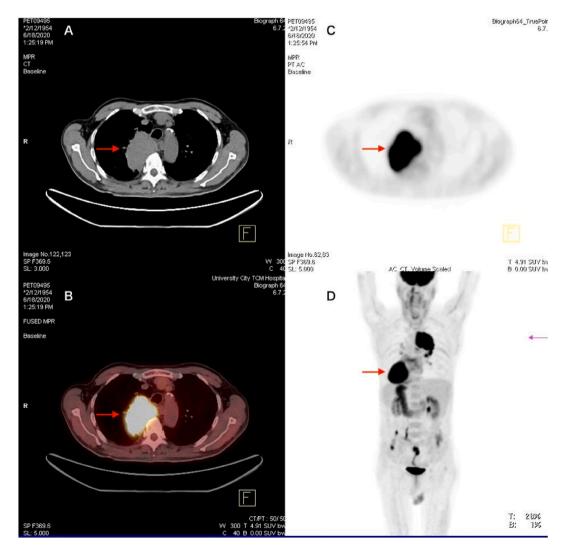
Evaluation by FDG PET-CT during the diagnostic process. The mass in the right lung's superior lobe (indicated by arrow) was identified as the primary tumor.
